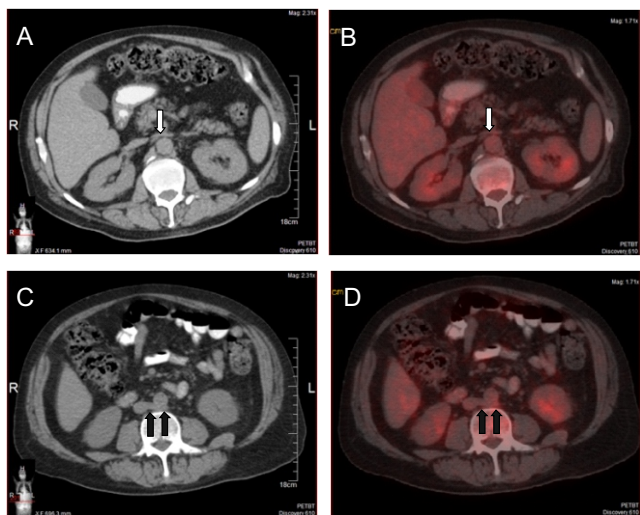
Axial plain CT (A, C) and fused PET/CT (B, D) images of CLRV (white arrows: preaortic component, black arrows: retroaortic component).
